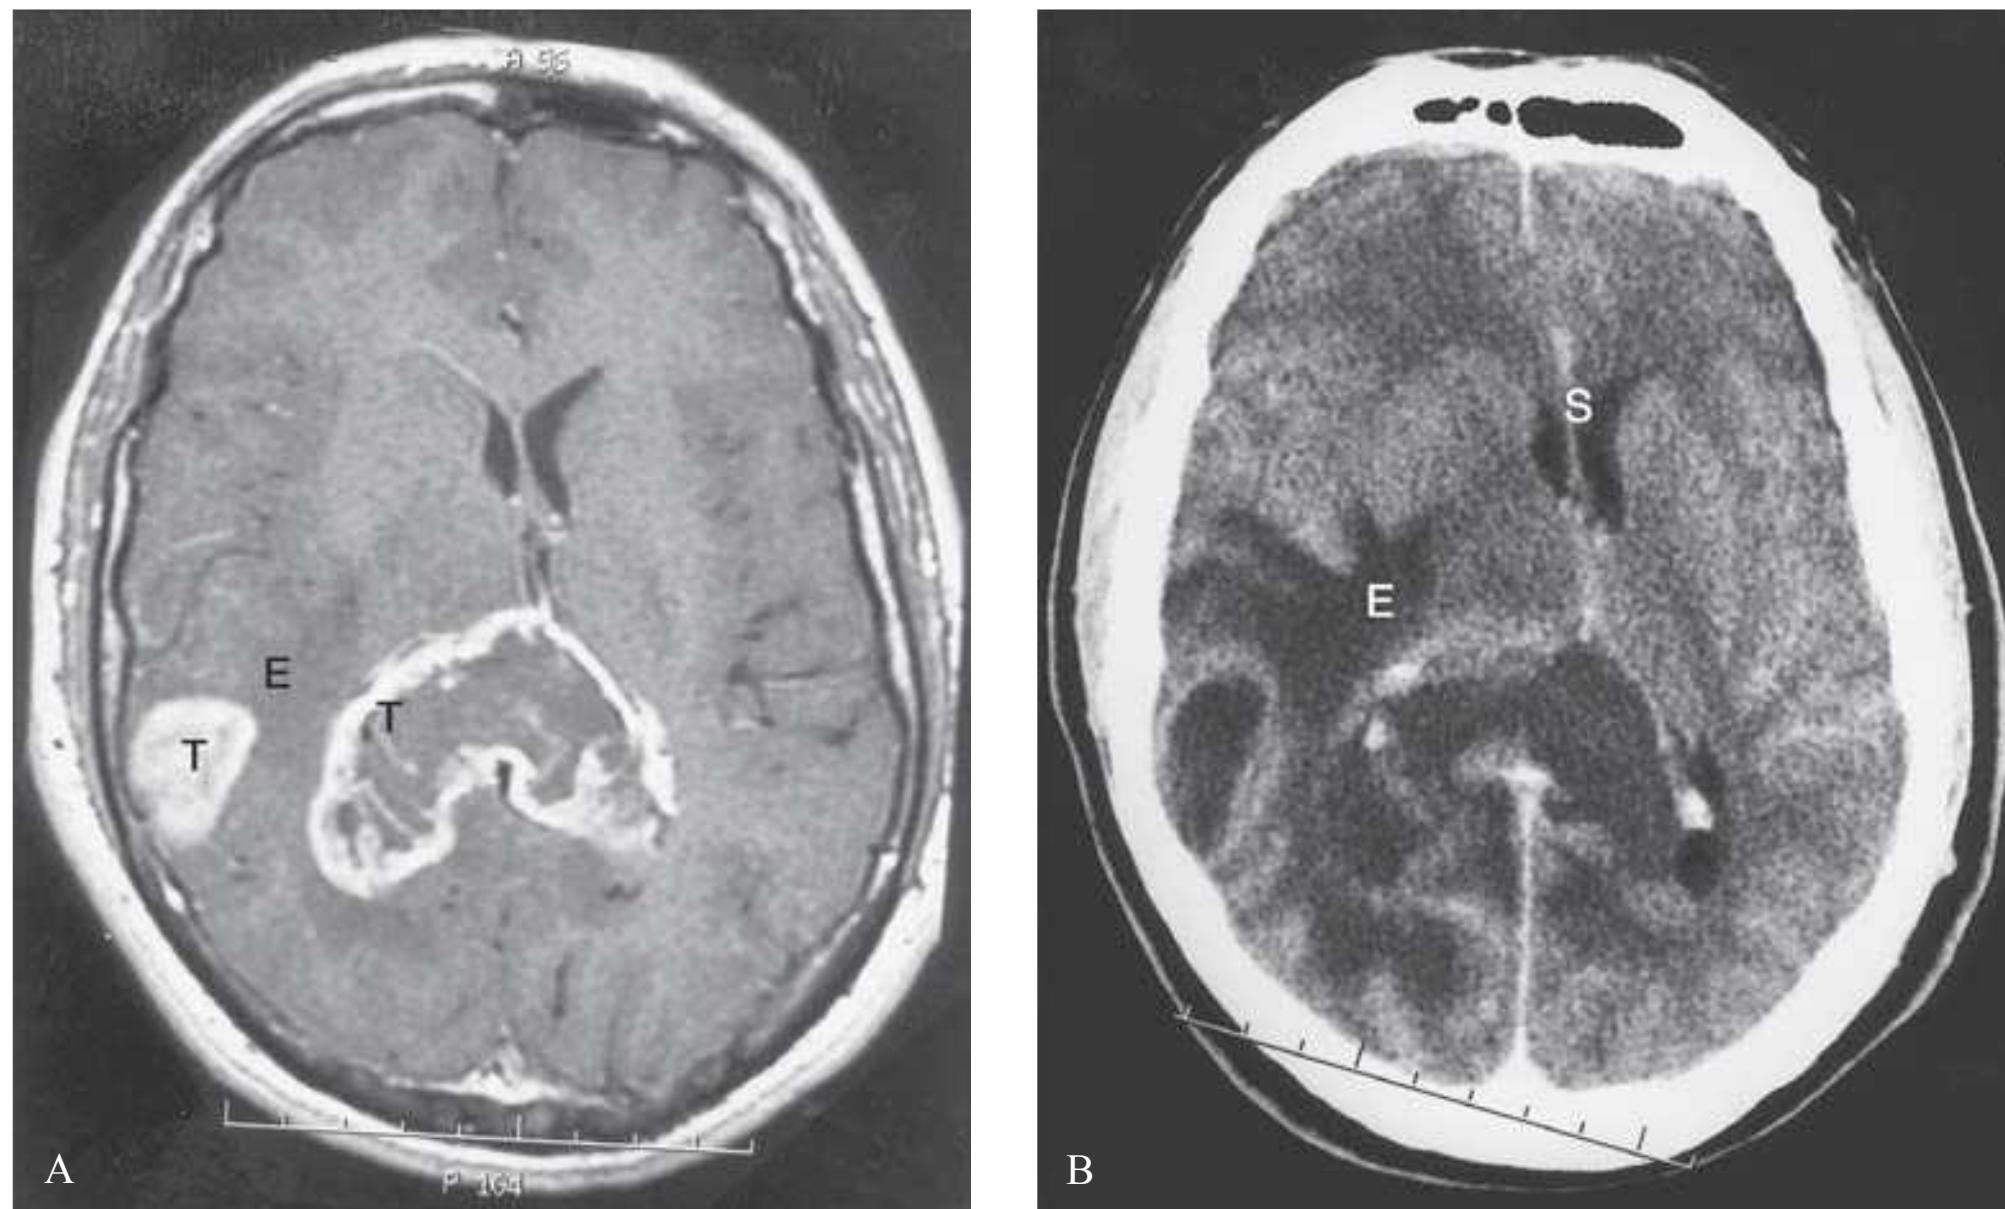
A: This magnetic resonance imaging, performed on a patient presenting with headache and memory lapses, shows an enhancing mass (T) involving the corpus callosum and right parietal area, with surrounding edema (E). Stereotactic biopsy revealed glioblastoma multiforme. B: One week following biopsy, the patient was admitted to the intensive care unit with obtundation and left hemiparesis. His computed tomography shows increased edema (E) and right-to-left midline shift (S)—parafalcine herniation. He required mannitol, increased Decadron, and surgical decompression to improve.
